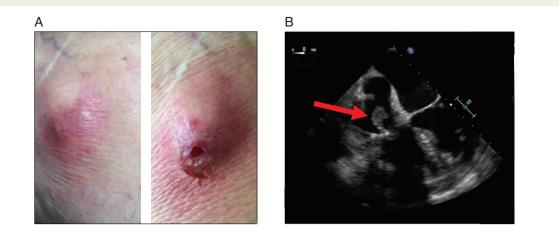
(A) Device pocket infection with perforation 1 week later. (B) Transoesophageal echocardiography showing a large vegetation attached to the tricuspidal valve and right ventricular lead.
